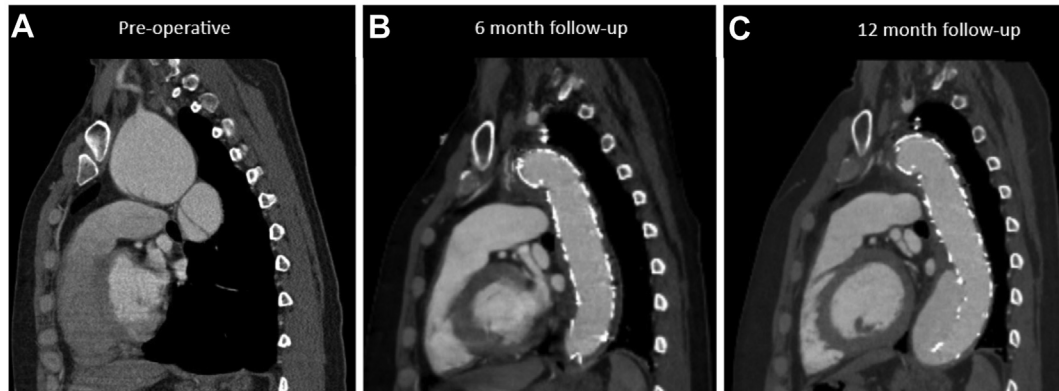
(A) Preoperative computed tomography angiography (CTA) sagittal view demonstrated degeneration of the aortic arch up to 7 cm. (B) Postoperative 6-month follow-up sagittal view demonstrated excellent aortic remodeling after staged repair. (C) Postoperative 12-month follow-up sagittal view demonstrated new degeneration of the distal thoracic aorta.
